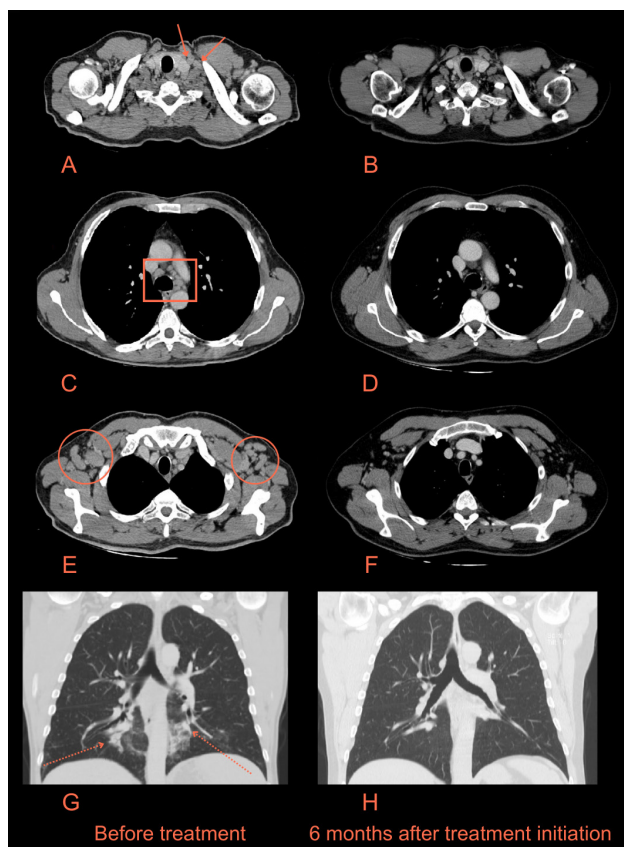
CT images of the neck and thorax before treatment (A, C, E, G) and six months after immunotherapy initiation (B, D, F, H). Note the cervical (arrows on A), mediastinal (rectangle on C) and axillary (circles on E) lymphadenopathy and foci of consolidation (dashed arrows on G) with surrounding ground-glass opacities. The CT performed six months after treatment showed no cervical or axillary lymphadenopathy and resolution of the pulmonary findings.
